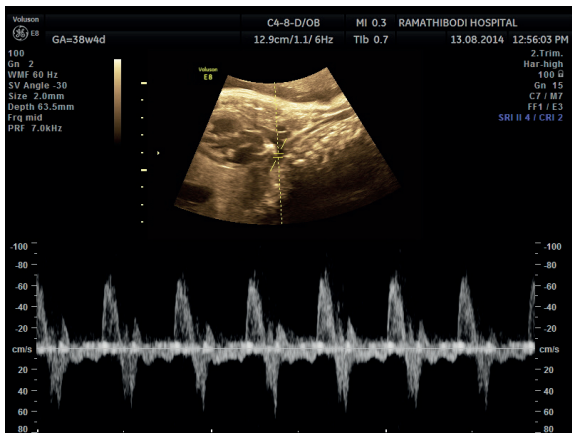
Measurement of aortic isthmus Doppler.
